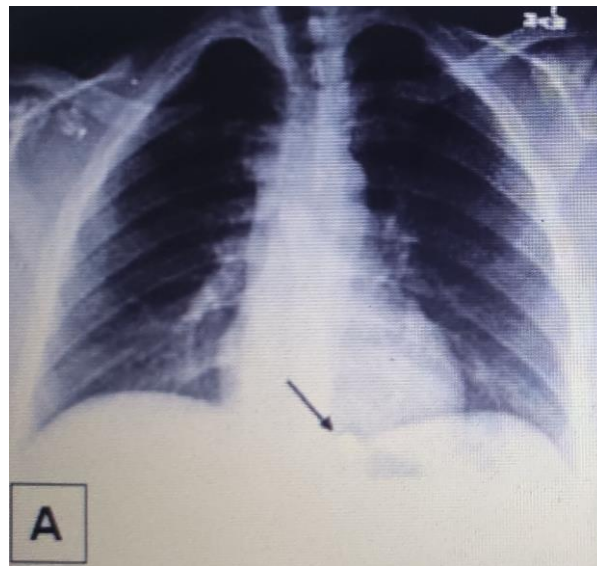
Antegrade bullet embolism. The serviceman was wounded in the right shoulder. When the wound was examined, no bullet was found; instead, he complained of chest pain. X-ray (A) and CT (B) of the chest were performed. A metallic foreign body is visualized in the cavity of the right ventricle. C. surgical removal of the bullet.
